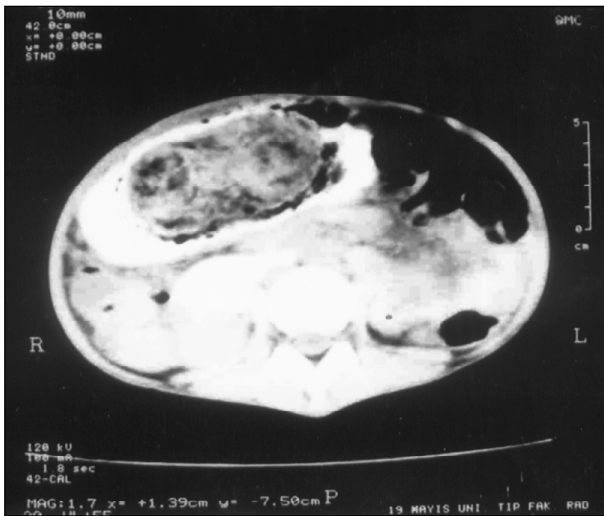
CT showing a mass in the stomach.
